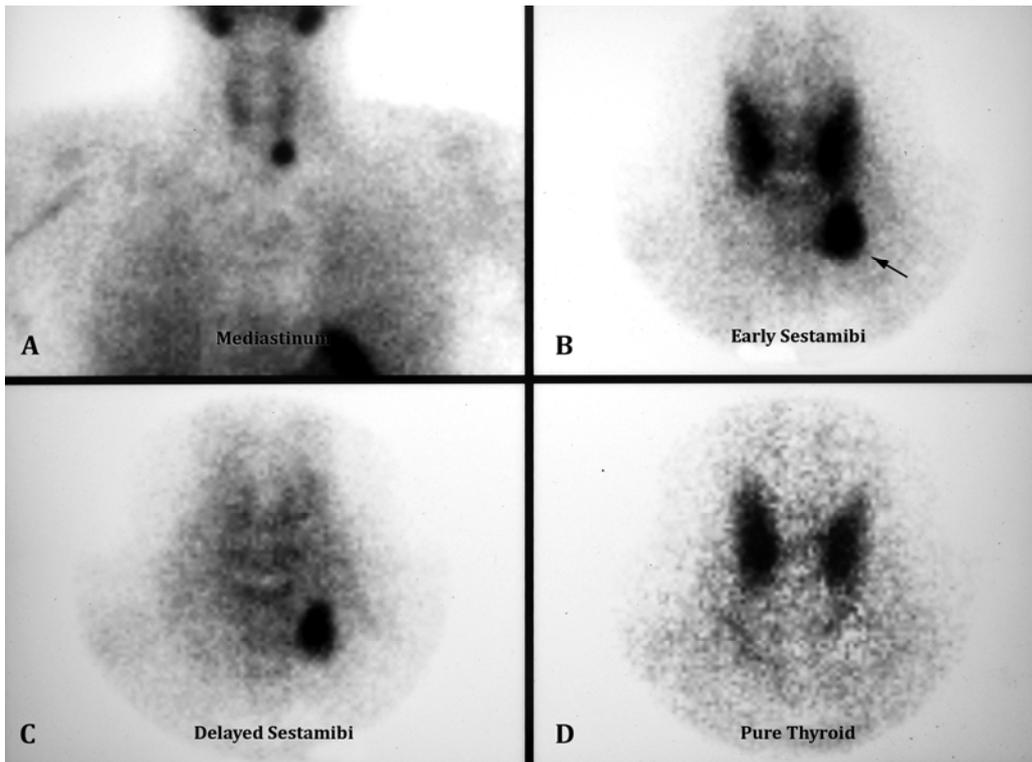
Dual-phase parathyroid scintigraphy of mediastinum (panel A) and neck (panels B to D). A focal area of abnormal activity is seen just inferior to left thyroid lobe in early ^{99m}Tc -sestamibi images (panel B). It persists in the delayed images (panel C) and is not present in pure $^{99m}\text{TcO}_4$ - thyroid image (panel D).
